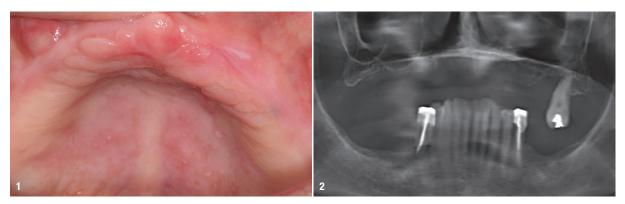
Initial situation (after third molar extraction). Fig. 2: Panoramic radiograph.
